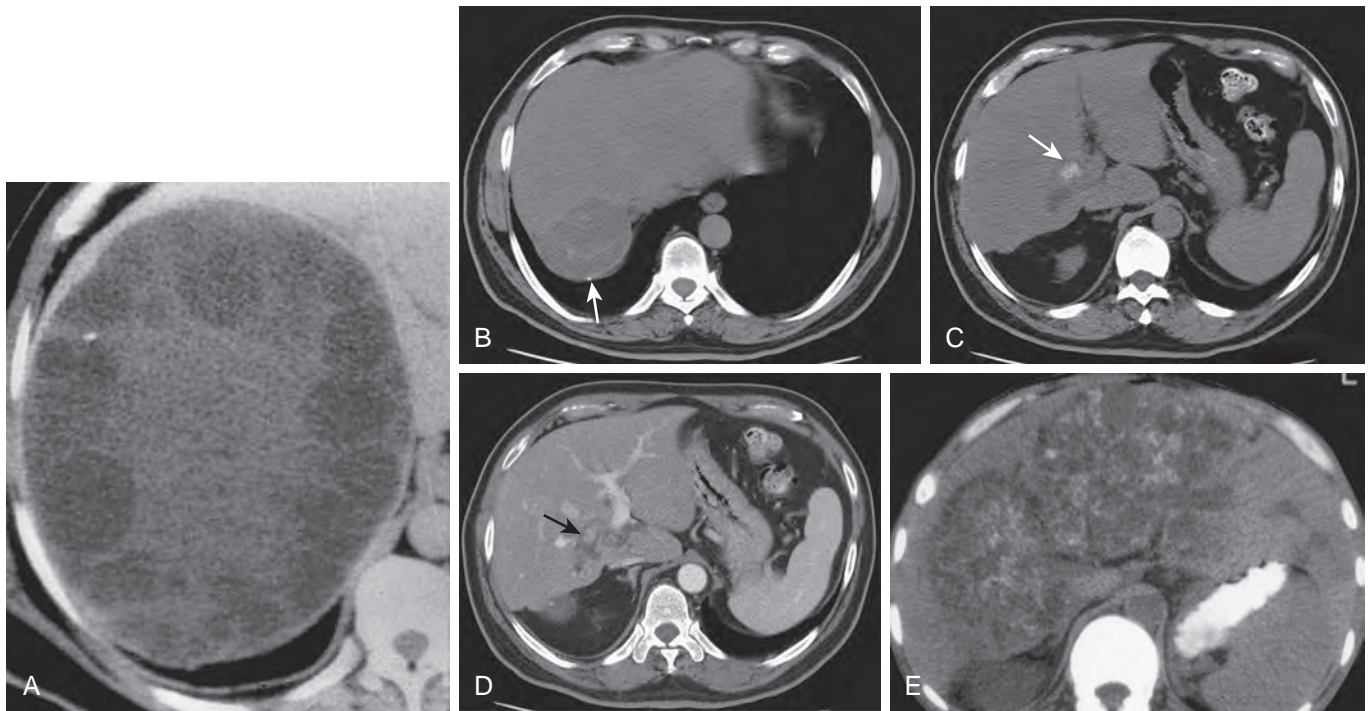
Hydatid disease: CT findings. A. CT scan shows a large multilocular cyst with a thick wall. Multiple daughter cysts line the periphery of the mass. B. Calcification is seen within the dominant cyst in the right lobe on this noncontrast scan. C. More caudal scan shows intrabiliary passage of hyperdense cyst contents (arrow). D. Contrast-enhanced scan at the same level as C demonstrates filling defects (arrow) within dilated intrahepatic bile duct. E. Precontrast scan in a patient with *E. alveolaris* demonstrates an extensive, infiltrative lesion with calcifications in the right lobe.
